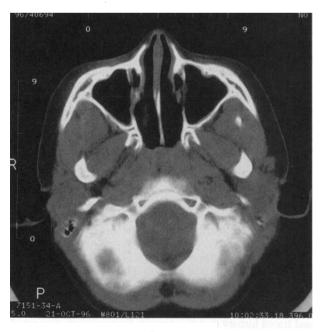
Axial MRI scan revealing mass in nasopharynx.
